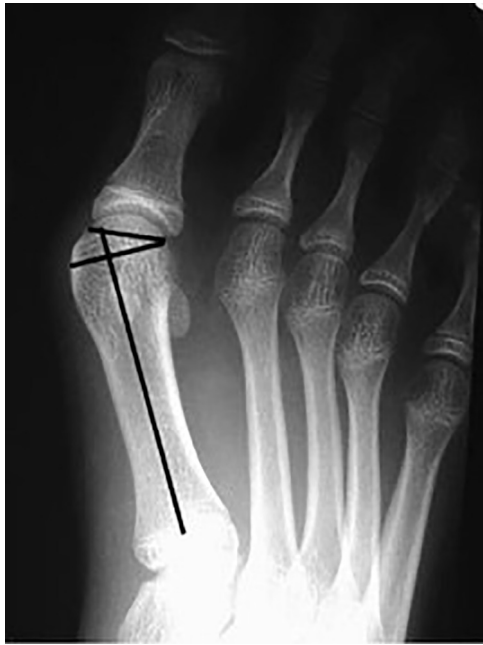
A hallux valgus radiograph of a juvenile showing the distal metatarsal articular angle of the hallux.
